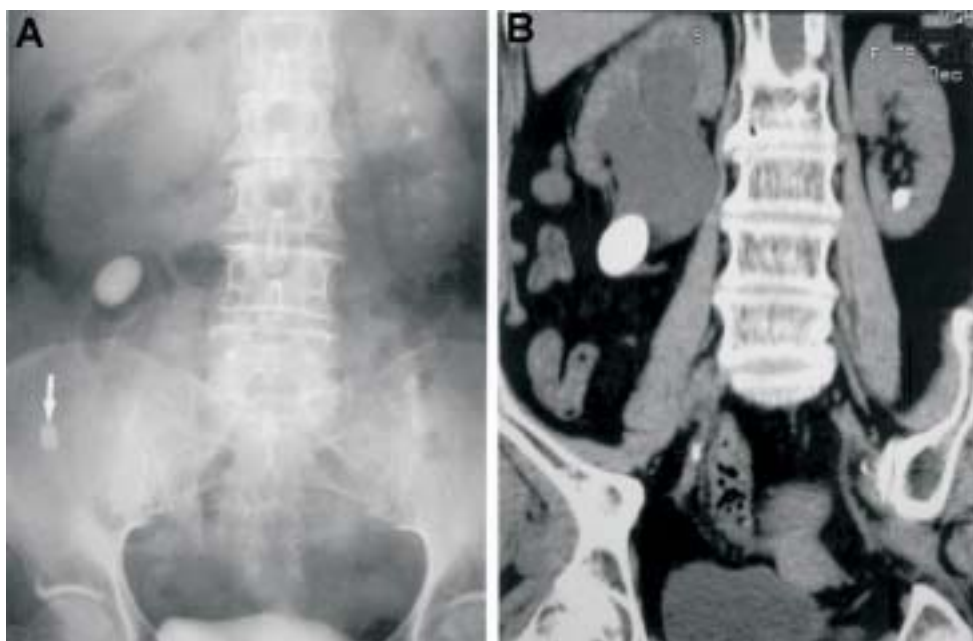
A 79-year-old male patient presented with acute right flank pain. (A) The intravenous urography (IVU) shows 1 calcified stone at the right flank region. The right kidney is not opacified due to deterioration of renal function. Therefore, the obstruction level of urinary tract cannot be shown. (B) Non-contrast CT urography clearly demonstrates stone located at right uretero-pelvic junction with marked right hydronephrosis. An appendicolith noted in Fig. 1A (arrow) is also depicted by the CT scan as an associated finding.
